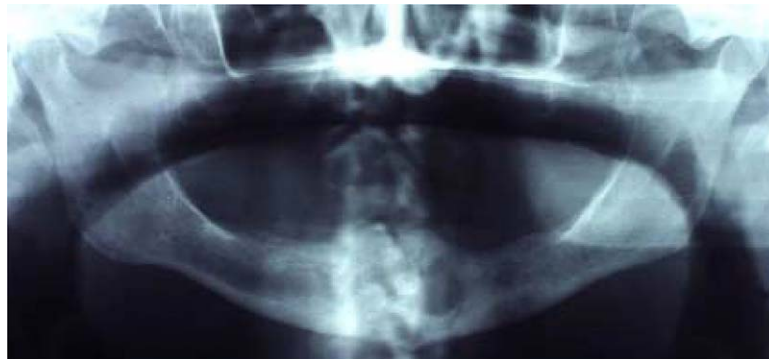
Panoramic radiographs demonstrates an unilocular radiolucent lesion in the left anterior mandible.
